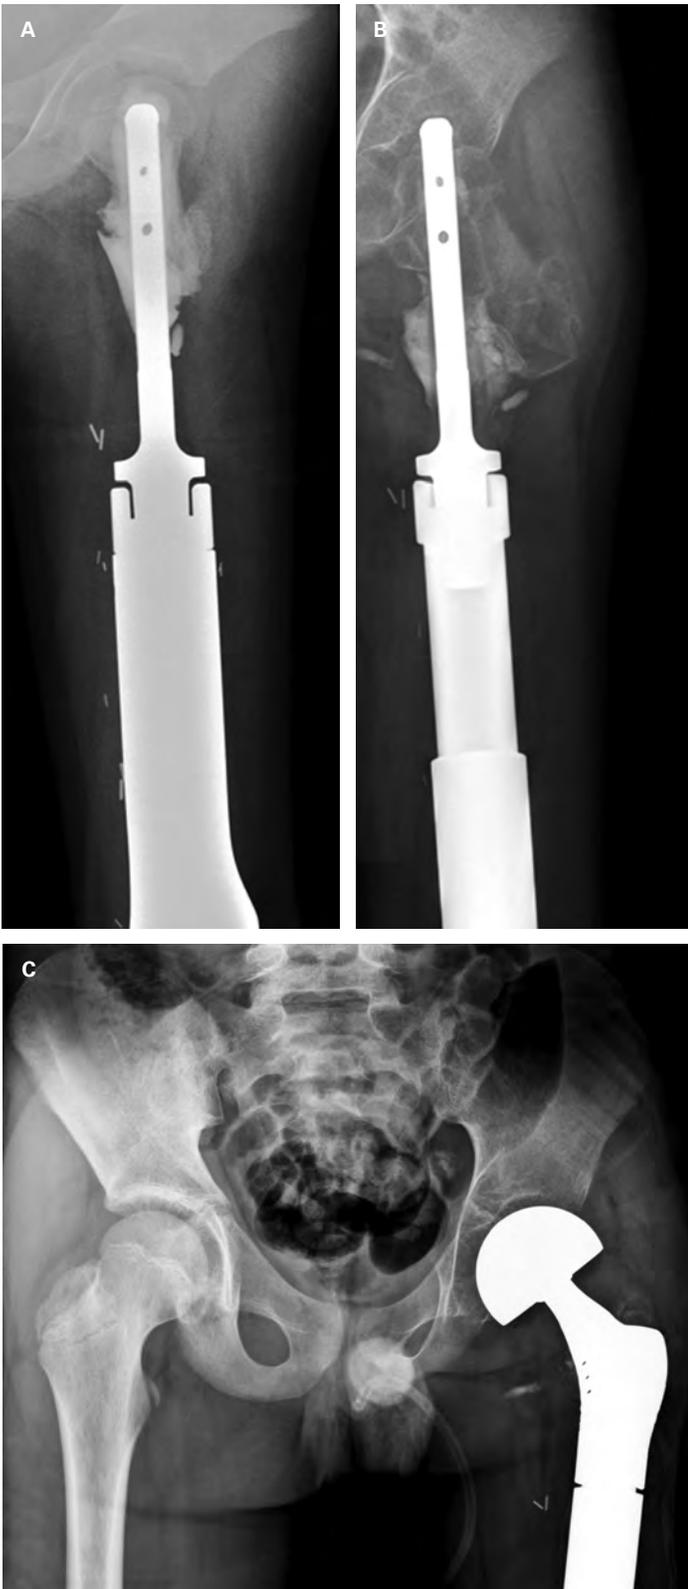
Seven-year-old boy with left distal femoral osteosarcoma undergoing reconstruction with a second generation expandable endoprosthesis (case one). (A) AP plain radiographs view showing distal femoral reconstruction after intertrochanteric osteotomy and verticalization of the proximal femur. (B) AP plain radiograph showing distal femoral reconstruction and proximal migration of the femoral stem- note the area of expansion within the femoral stem. (C) AP pelvis plain radiograph showing proximal femoral bipolar hemiarthroplasty after revision surgery due to proximal migration of the femoral stem.
